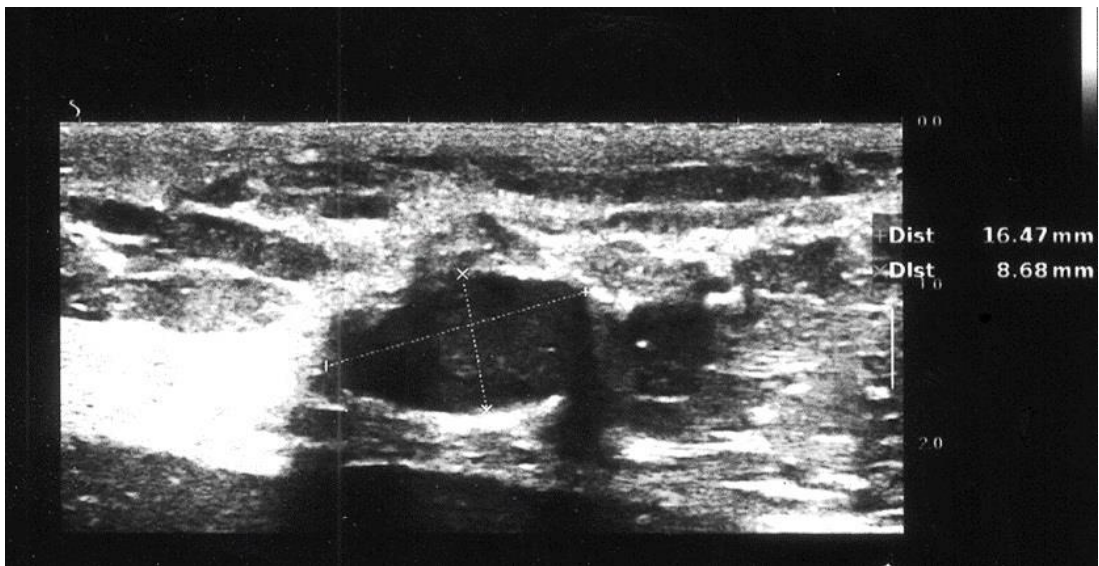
Transverse ultrasonography shows a bizarre shape hypodense nodule at the repaired site of the Median nerve after surgical repair of previous trauma
